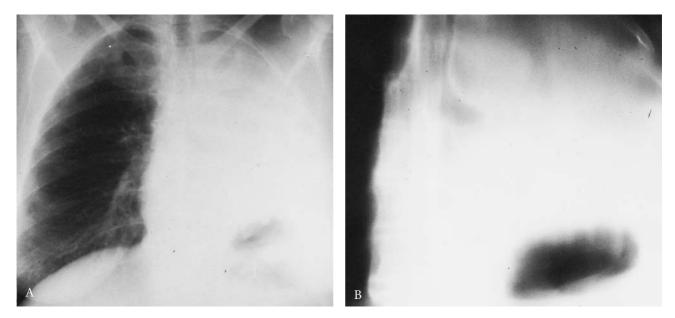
Missed left main bronchial stenosis due to missed bronchial rupture. Posteroanterior chest radiograph* (A) *and anteroposterior tomogram* (B) *reveal collapse of the left lung distal to a left main bronchial stenosis.*
